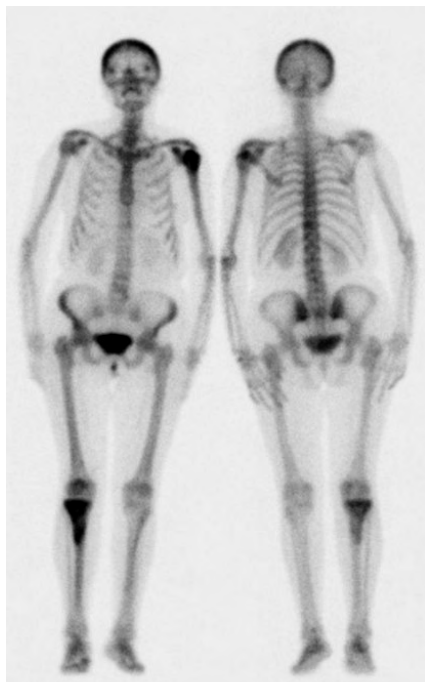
Whole body bone scintigraphy demonstrating hot spots in the right tibia and the left humerus.
